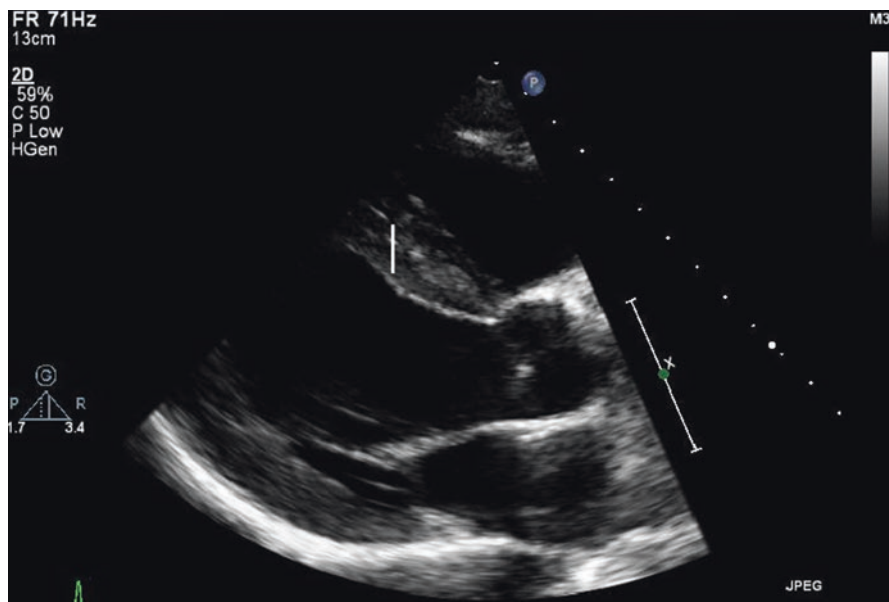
Echocardiography and structural changes in endurance athletes
